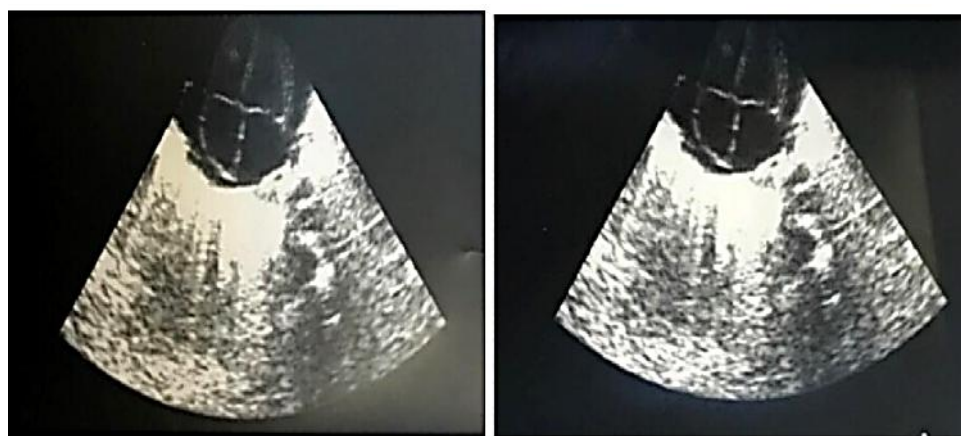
Echocardiography after pericardiocentesis
